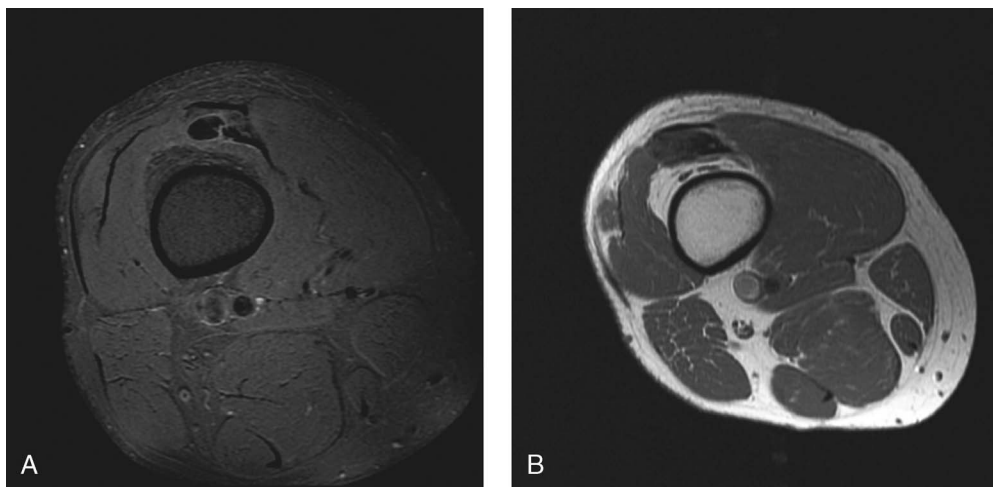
Axial MRI images of the quadriceps tendinopathy and tears at the initial MRI (A), approximately 3 months after the first PRP injection and thus 13 weeks after the initial MRI (B), and approximately 9 months after the initial MRI, which was about 1 wk after minor pain flare reported by the patient during mountain hiking (C). Special care was taken with these images to select slides at similar anatomic levels for consistency in interpretation of the images.
